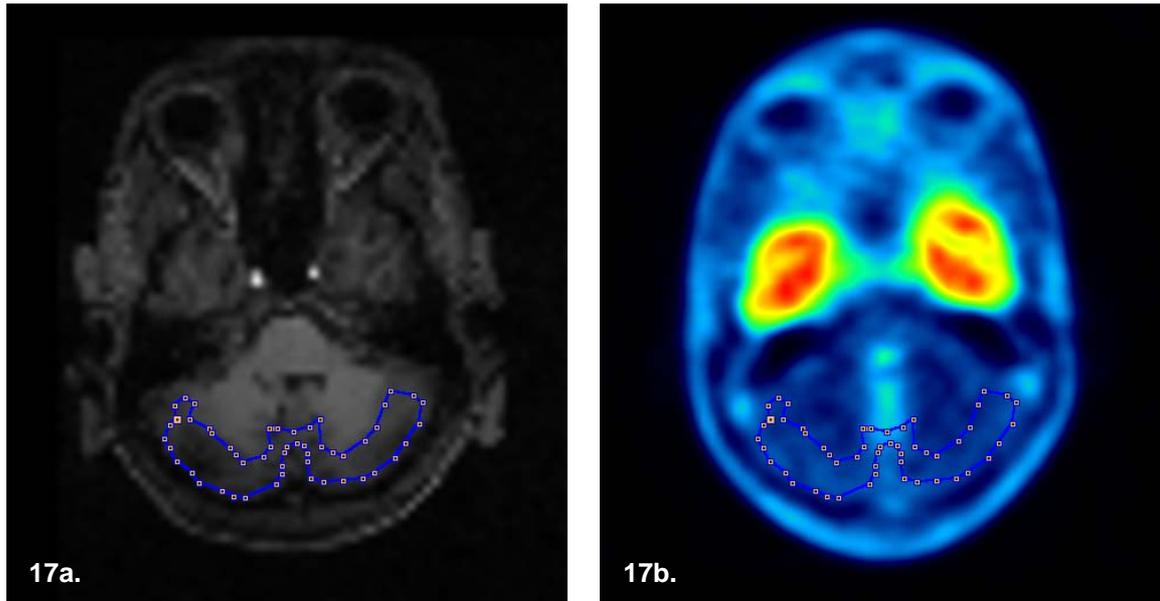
Cerebellum ROI of a single subject on the co-registered MR image
